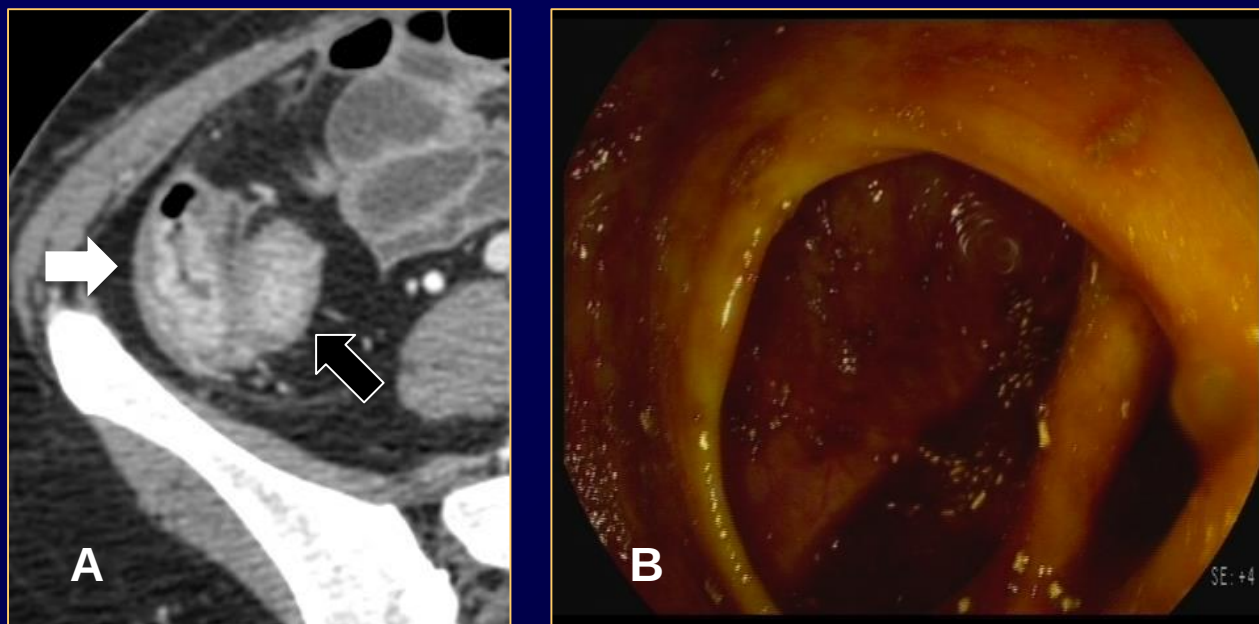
PEG-CT (A) shows thickening of the cecum (white arrow); thickening of the last ileal loop is also evident in the image (black arrow). Endoscopy shows no alteration in the colon (B) and confirms ileal loop alteration (not shown)
